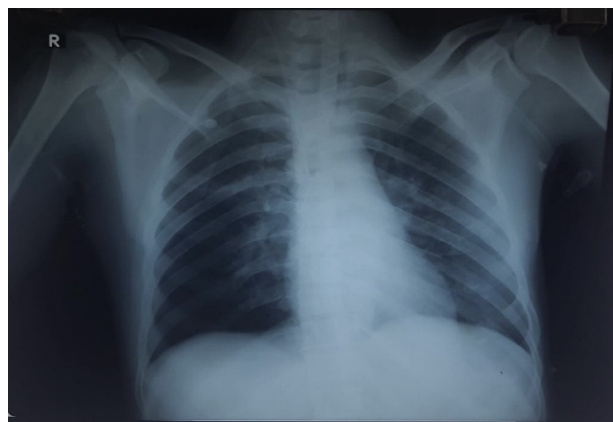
Chest radiograph demonstrating bilateral diffuse opacities consistent with aspiration pneumonitis in the setting of decreased consciousness and vomiting.
